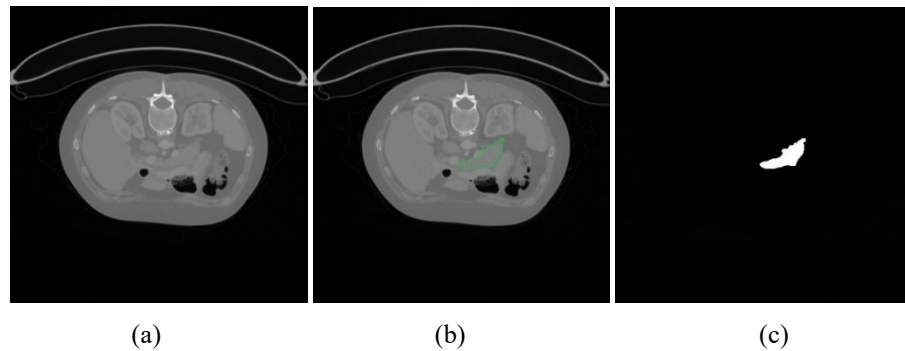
A CT image from the TCIA database (512x512 pixels): (a) Original image, (b) Labeled image, (c) Mask
